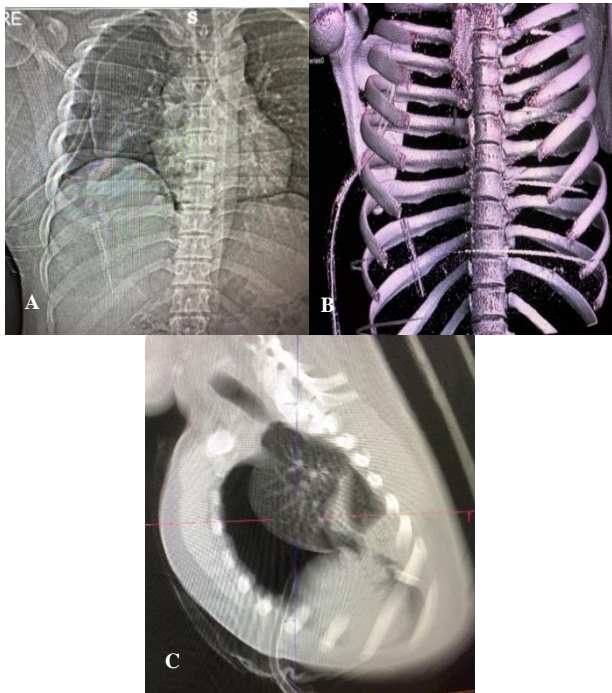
(A) Post procedure X-ray after ICD insertion showing the broken piece below. (B) 3D reconstruction showing broken piece of chest tube lodged in the pleural cavity. (C) Lateral view showing the broken piece lodged in the posterior diaphragmatic recess.
